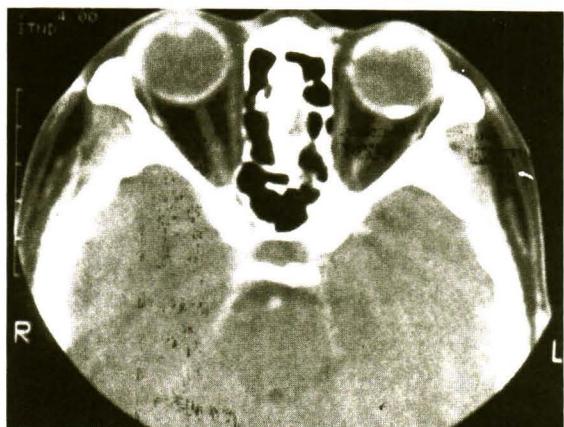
Patient 3. Enhanced axial CT scan of the left orbit demonstrates a moderate calcific choroidal plaque posterolateral to the left optic nerve insertion.
